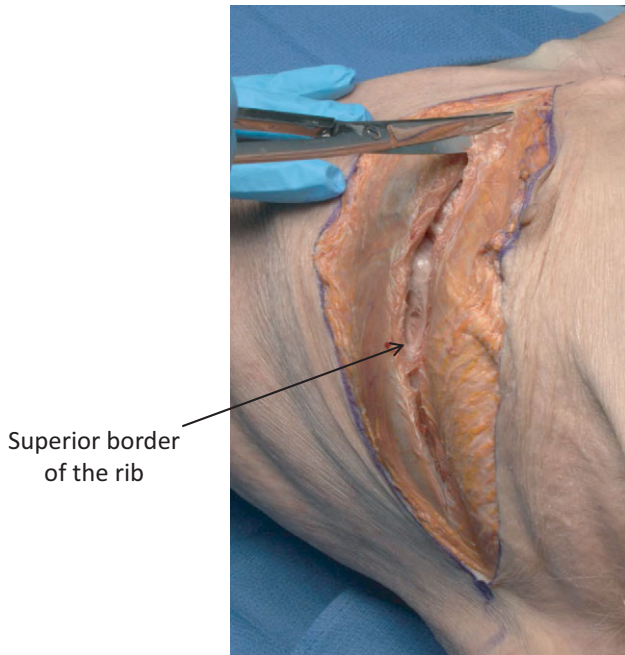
(a, b) The incision for an anterolateral thoracotomy is placed through the fourth to fifth intercostal space, starting from the parasternal border and extending to the posterior axillary line, aiming towards the axilla. (c, d) The pectoralis muscle is the first muscle encountered and divided. The lower portion of the pectoralis minor muscle is found beneath the pectoralis major muscle and divided.
